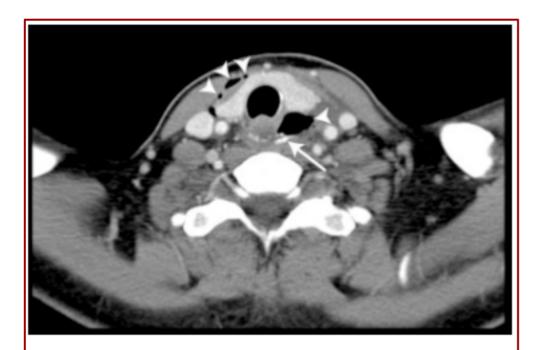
CT scan of the neck with dilute Gastrografin® demonstrating periesophageal air leaks (arrowheads) and extravasated contrast (arrow), confirming and localizing esophageal perforation.
